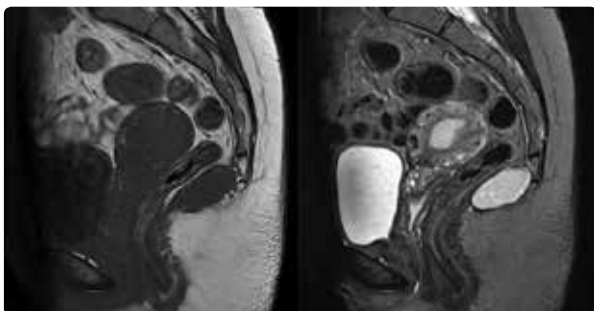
Axial plane image of the lesion in T1 and T2 weighted magnetic resonance imaging.
